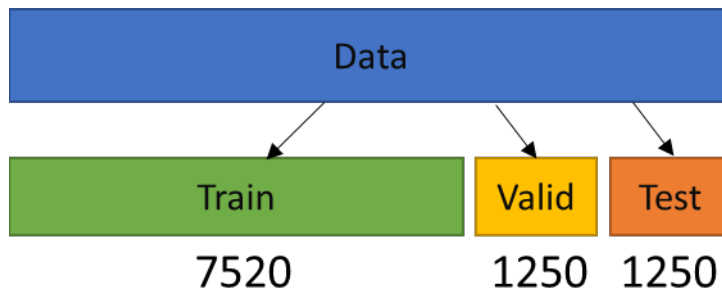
Echocardiogram data was split into training, validation, and testing subsets.
